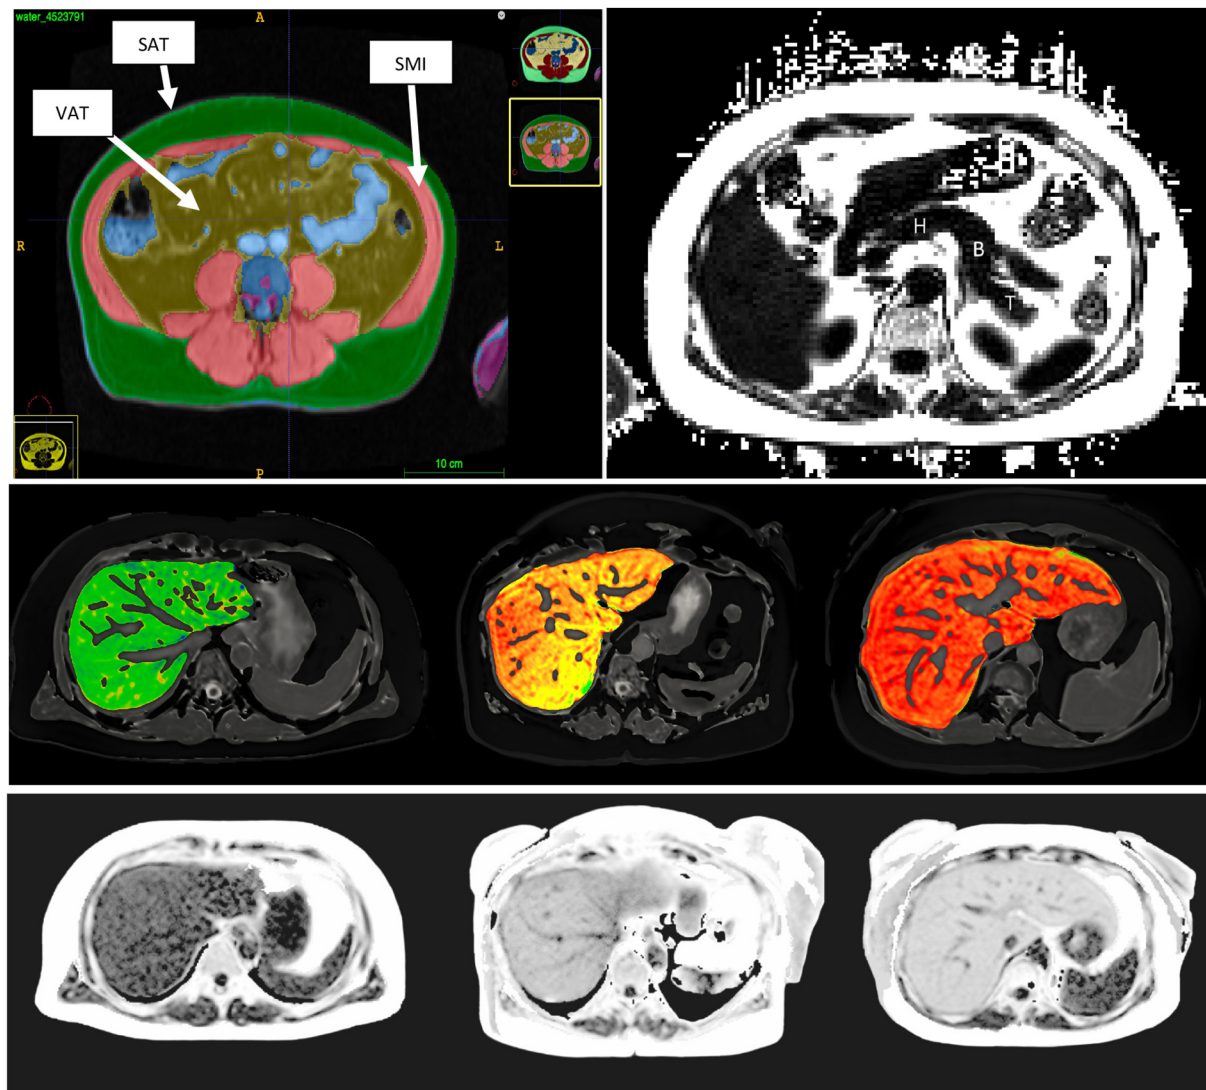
Example magnetic resonance images of body composition segmentation (top left), pancreas (with example of typical region of interest placement [H = head, B = body, T = tail; top right]), liver corrected T1 (cT1) (middle), and liver proton density fat fraction (bottom). SAT, subcutaneous adipose tissue; SMI, skeletal muscle index; VAT, visceral adipose tissue
